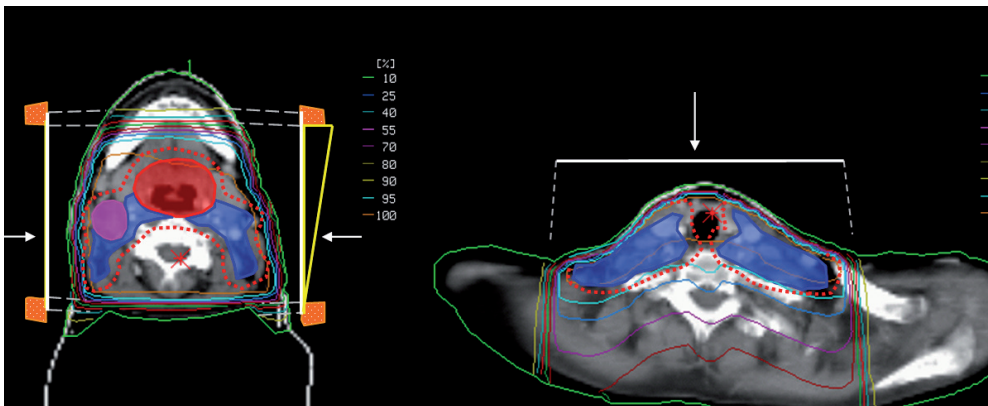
See legend figure 20. Dose (46/2 Gy) distribution axial CT slice upper neck and low anterior neck. Dose generally prescribed at 3cm depth or at a particular point of interest (e.g. in case of lymphnodes in lower neck). Note: no midline block because of potential shielding of tumor extensions.
